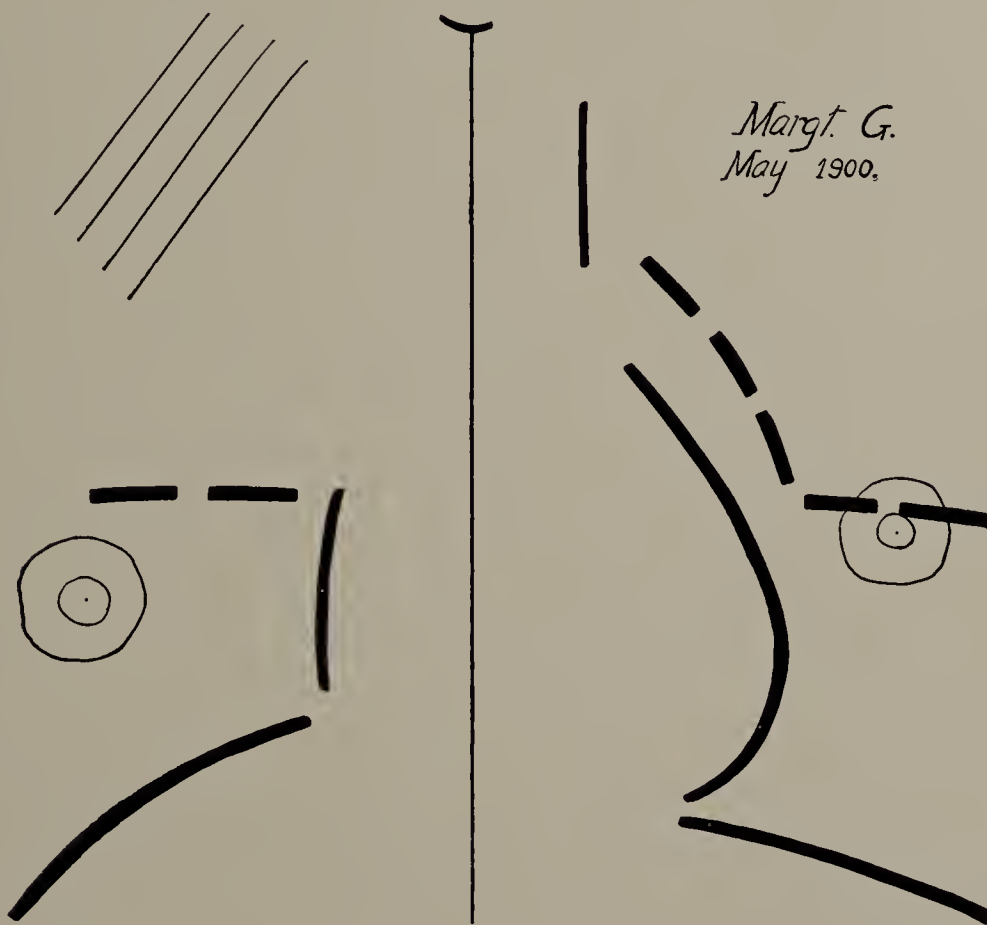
Margaret G. May 21, 1900. X-ray tracing. (One-third life size.) Right apex shaded; excursion of diaphragm shortened on this side.
